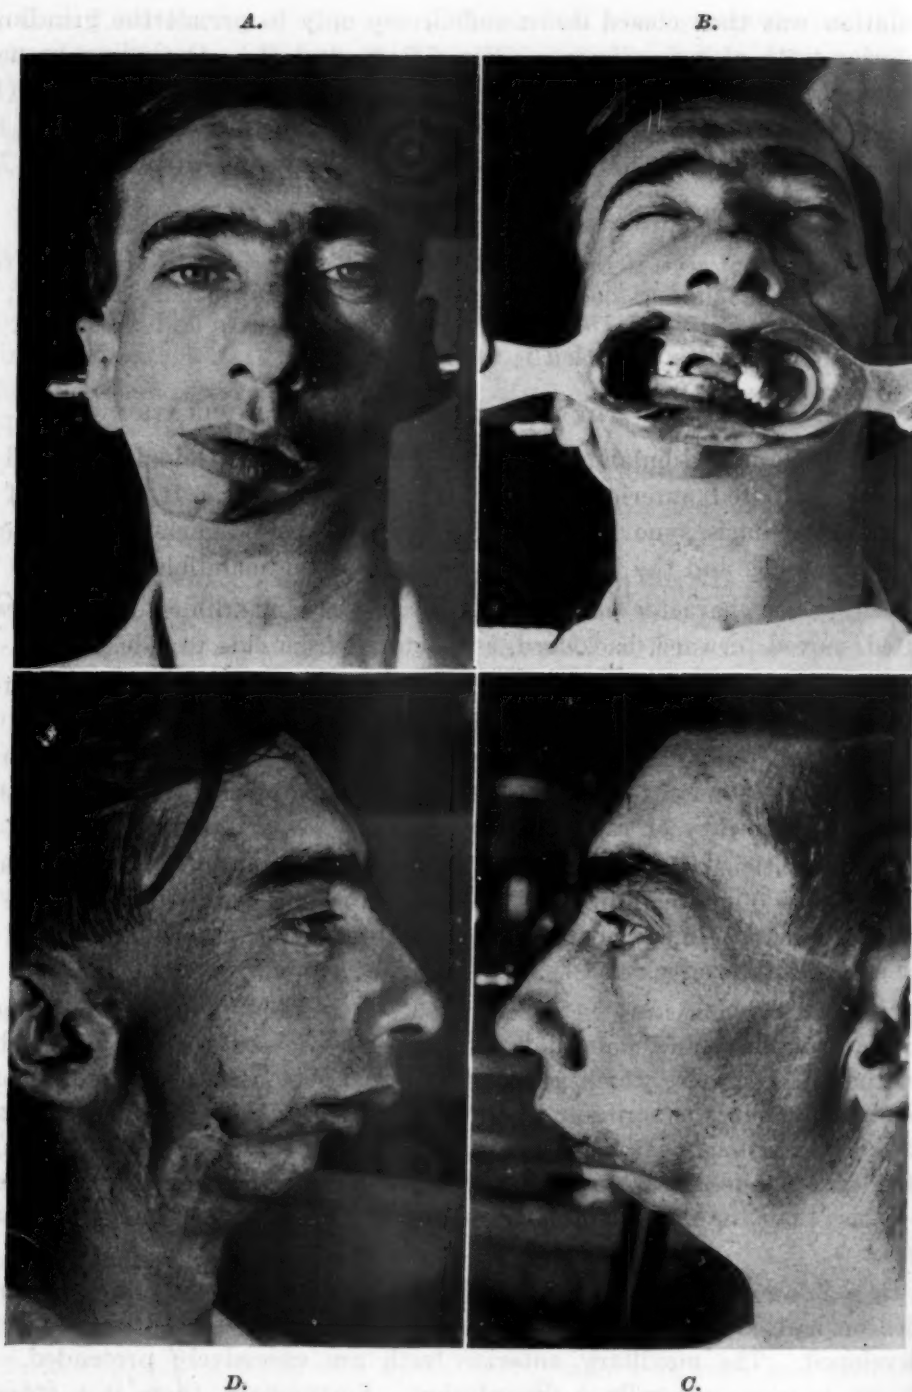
A*, Recurrent temporomandibular ankylosis, front view. *B*, Occlusal view. Forced maximum opening equals 8 mm. in premolar region between alveolar ridges. *C*, Left profile (normal side), but seems to be more flattened than affected side. *D*, Right profile appears more normal although it is the affected side. *E*, Maximum opening three years later. Caliper indicates 18 mm. without effort. *F*, Appliance with extension hooks for reverse intermaxillary force. *G*, Right profile roentgenogram indicates space between bone ends without appliance at beginning of treatment. *H*, Right profile roentgenogram with appliance in mouth, showing increased space between bone ends.
